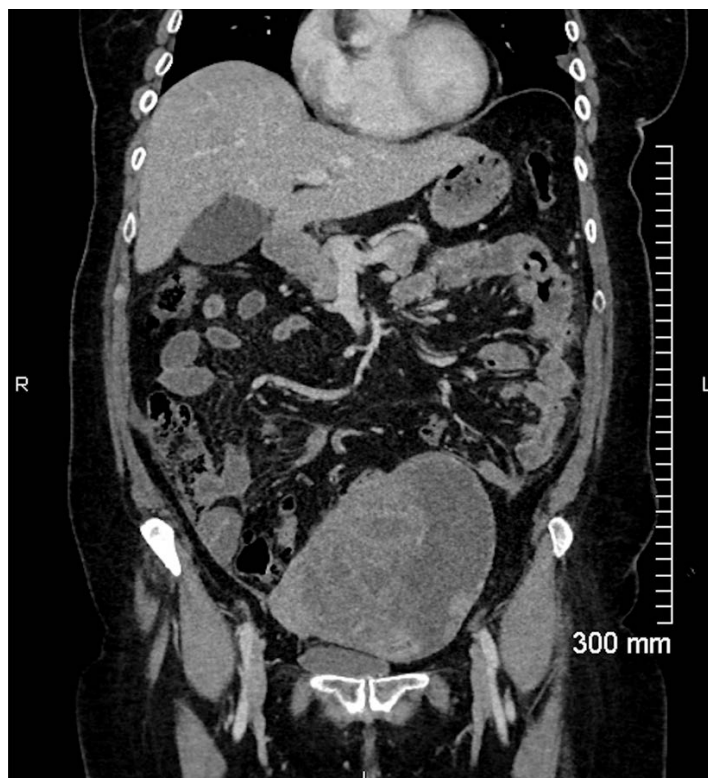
Coronal image from the portal venous phase abdominal CT shows a large pelvic mass measuring 14cm, predominantly solid with some cystic components, and trace free fluid in the pelvis.
